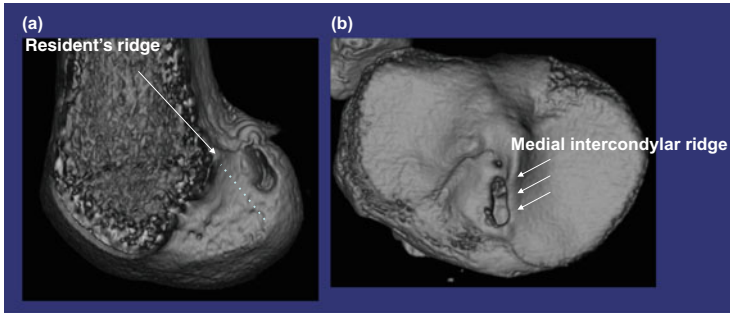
3D CT views on tunnel apertures after ART ACLR (*right knee*) (medial half of the femur is removed). (a) Femoral tunnel aperture; (b) tibial tunnel aperture
